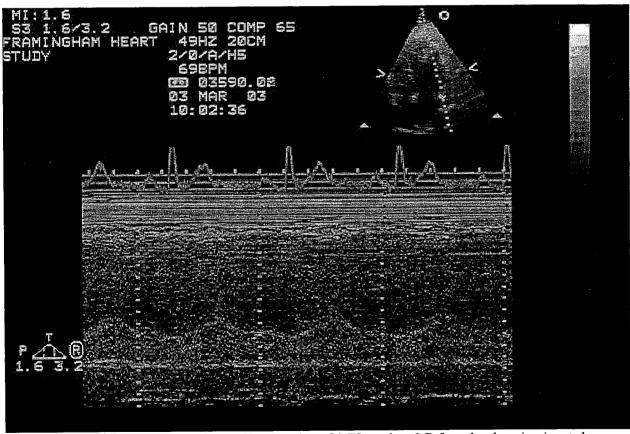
Example of M-Mode Apical Four-Chamber view of MV annulus. 2-D four-chamber view is not clear. Echoes of MV annulus movements are not well-defined and has a grainy appearance (suboptimal image).
